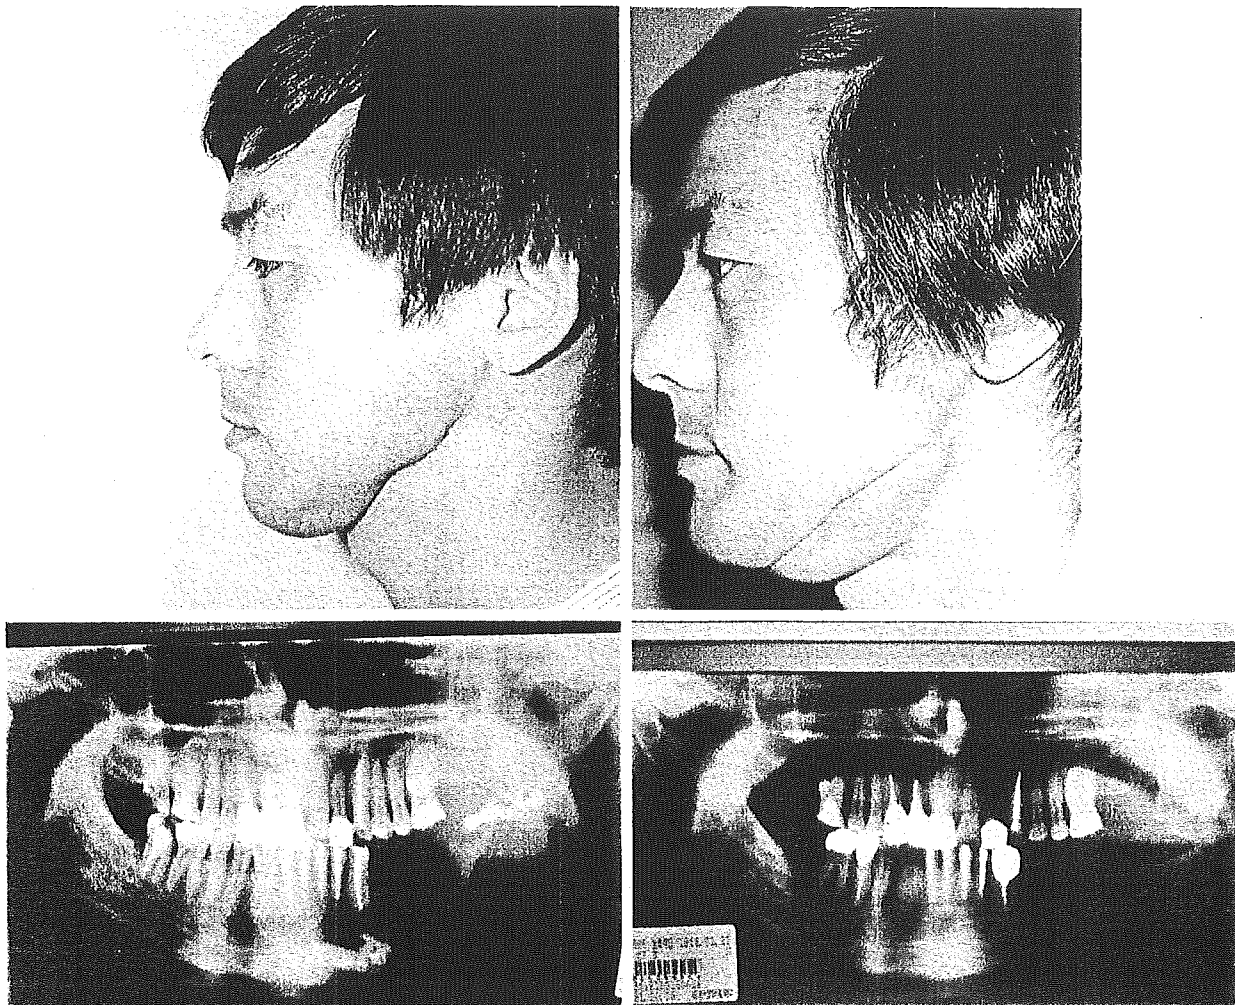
Case 1. (*Above, left*) Despite a previous bone graft and apatite implantation, this 32-year-old man had scar contracture with hemimandibular loss. (*Below, left*) Preoperative radiograph shows mandibular loss. (*Above, right*) Superficial circumflex iliac perforator flap at 7 months after the operation, which was resected later. (*Below, right*) Radiograph shows the vascularized iliac bone graft at 4 years after the operation.
